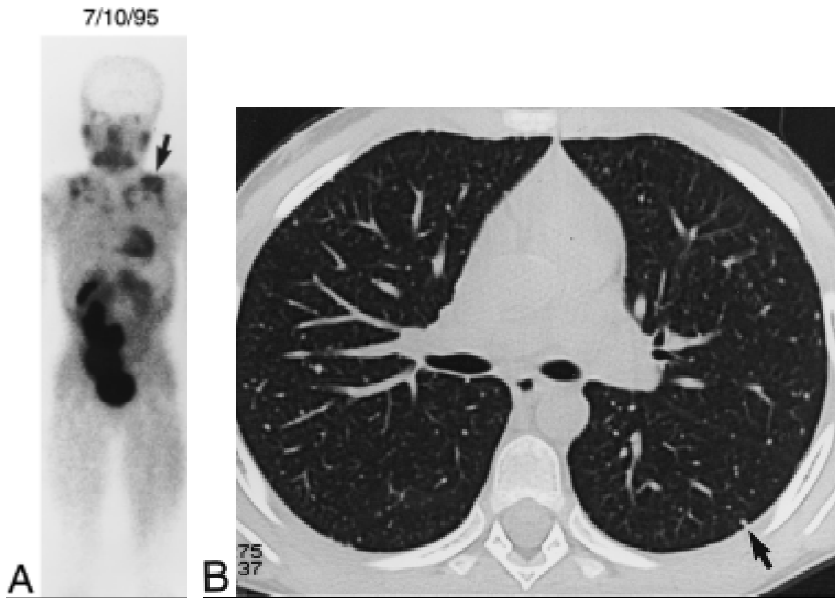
(A) ^{99m}Tc-sestamibi scan at first relapse showing uptake in the lung (arrow). (B) High-resolution chest CT at first relapse showing lung metastases (arrow).
